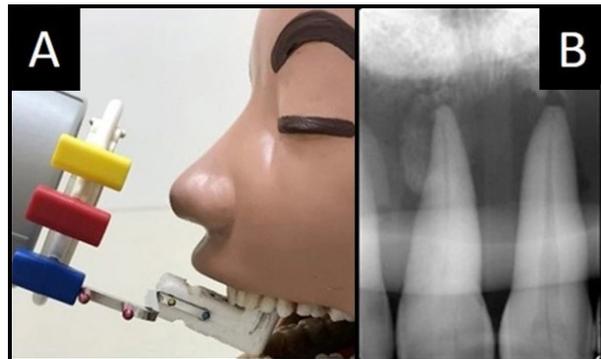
Maxillary anterior periapical
